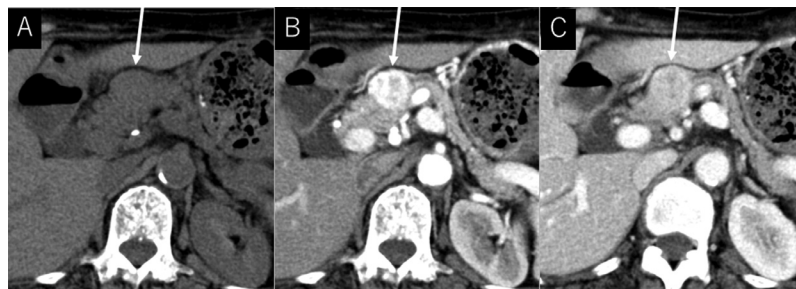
(A) Non-contrast-enhanced CT scan.
